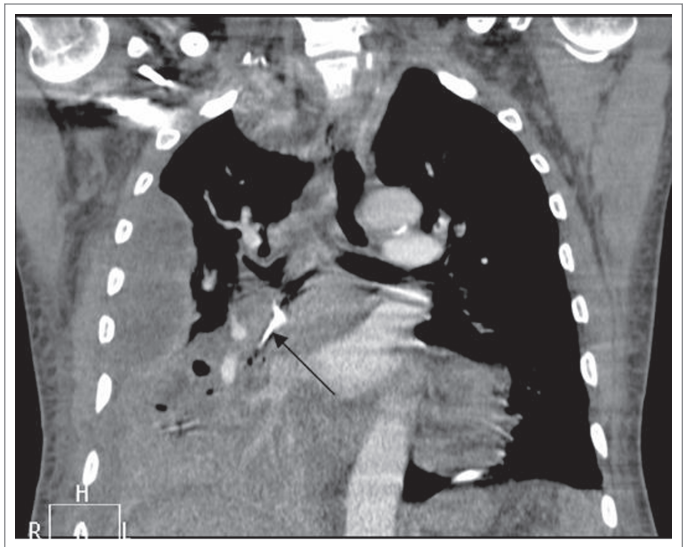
Coronal CT showing opacity in intermediate bronchus (arrow) with consolidation of right middle and lower lobes and a right pleural effusion.
